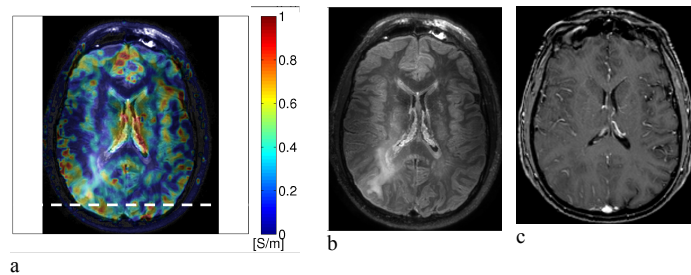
Patient 2: grade II astrocytoma a) Reconstructed conductivity map overlaid on a FLAIR image b) FLAIR c) post-contrast 3T T1W
